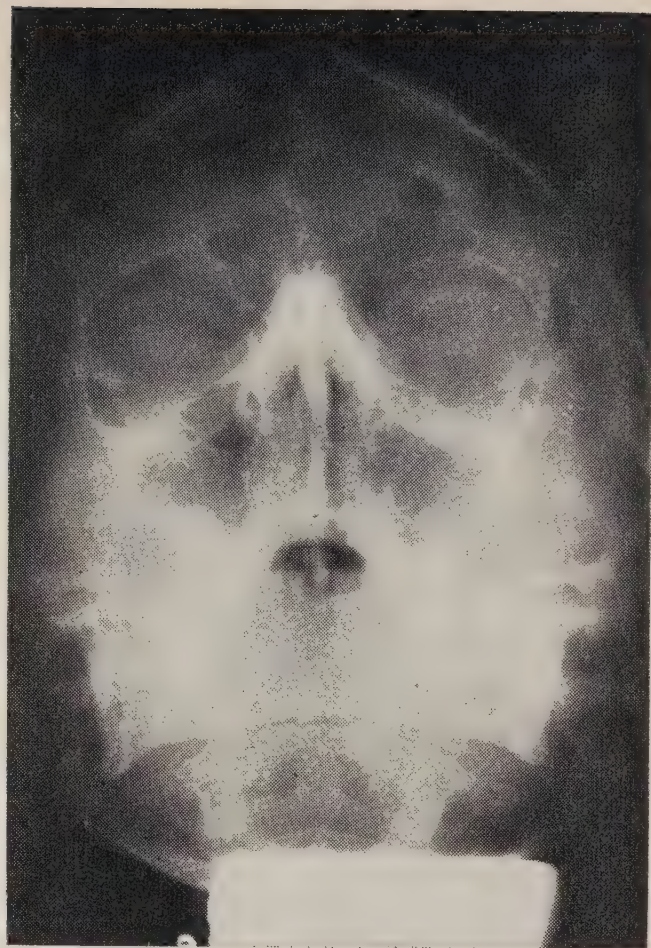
Waters view skull radiograph.
